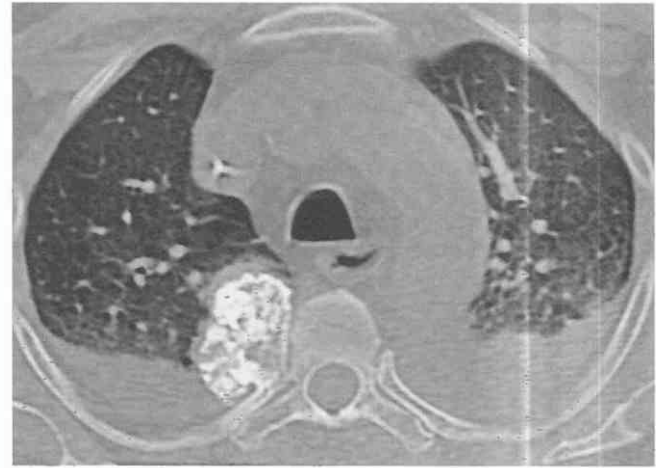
CT scan of osteochondroma. Noncontrast CT scan reveals a heterogeneous, lobulated, calcified mass with a cartilaginous cap arising from the right third rib, consistent with an osteochondroma.
